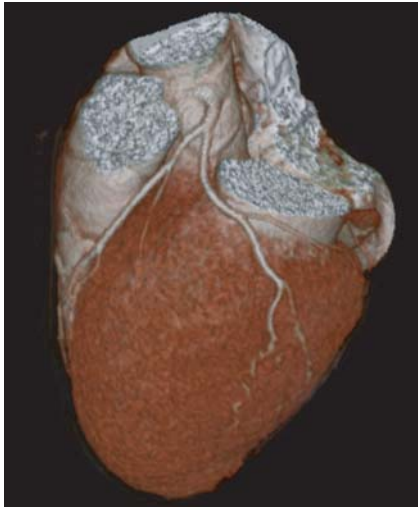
16-slice CT examination showing an ectopic origin of the LMA cranial to the left sinus of Valsalva; displayed with volume-rendering reconstruction
